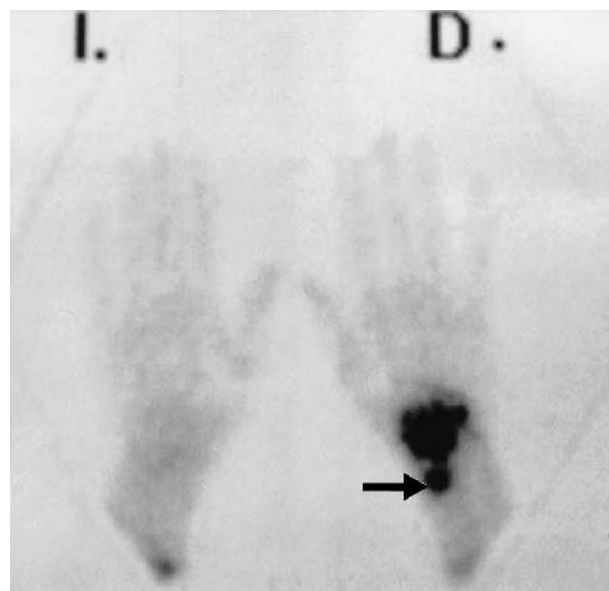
Three-month postoperative scintigram shows radionuclide uptake in the radius and extending across the carpus. The arrow shows MCD on the radius.
